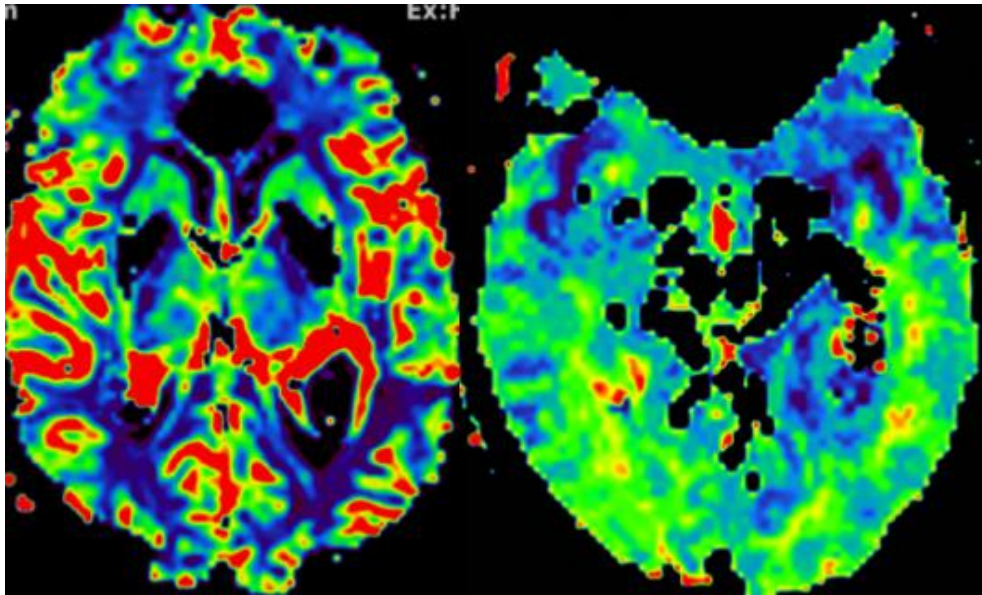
Perfusion MRI GBM.
